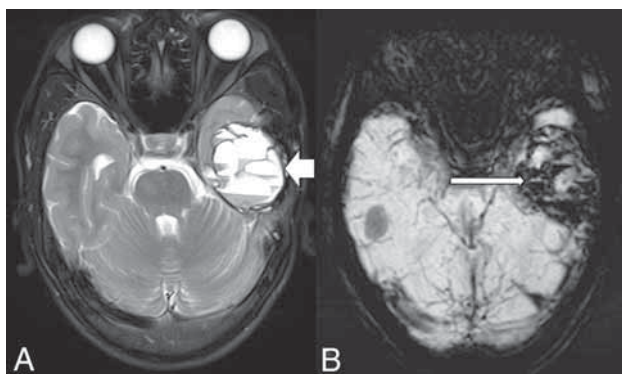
Multiloculated GCG of the left temporal bone with fluid-fluid levels (*short arrow, A*) on axial T2-weighted and layers of hypointense signal (*long arrow, B*) on a susceptibility-weighted imaging.
